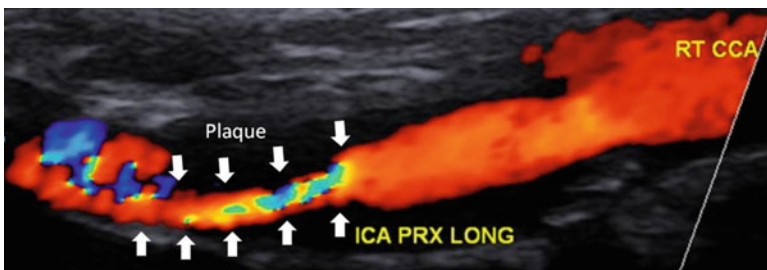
Image showing a hypoechoic (dark) plaque in the distal segment of the internal carotid artery. The color Doppler signal is not seen in the region of the plaque. The stenotic (narrowed) segment is indicated by the white arrows. Note that the color Doppler signal displays other colors (yellow, blue) in addition to the red color in the region of the stenosis and in the post stenotic segment. The appearance of other colors suggests higher velocity and turbulent flow
